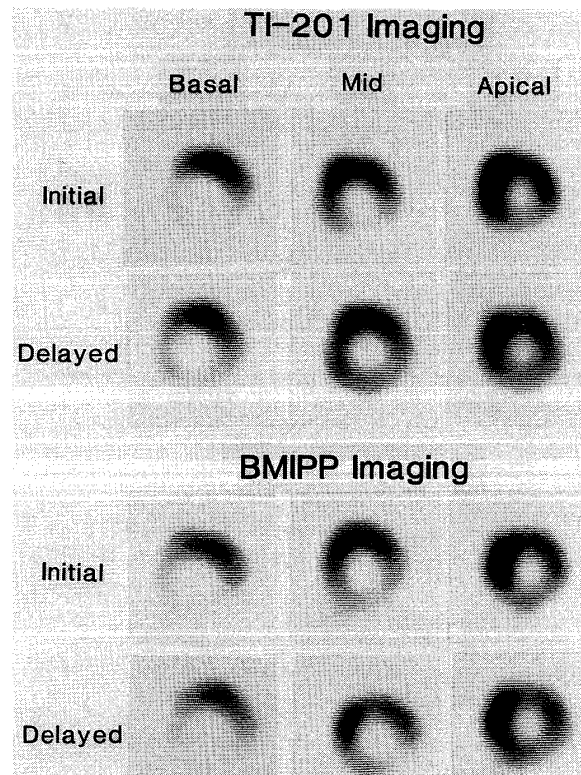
Exercise dual SPECT initial and delayed imaging with  $^{201}\text{Tl}$  (upper panel) and  $^{123}\text{I}$ -BMIPP (lower panel) in patient 5.  $^{201}\text{Tl}$  SPECT images show a transient defect in the inferior region. In  $^{123}\text{I}$ -BMIPP SPECT images, the uptake of  $^{123}\text{I}$ -BMIPP decreases similarly to the uptake of  $^{201}\text{Tl}$  in the same region, but does not show redistribution.
